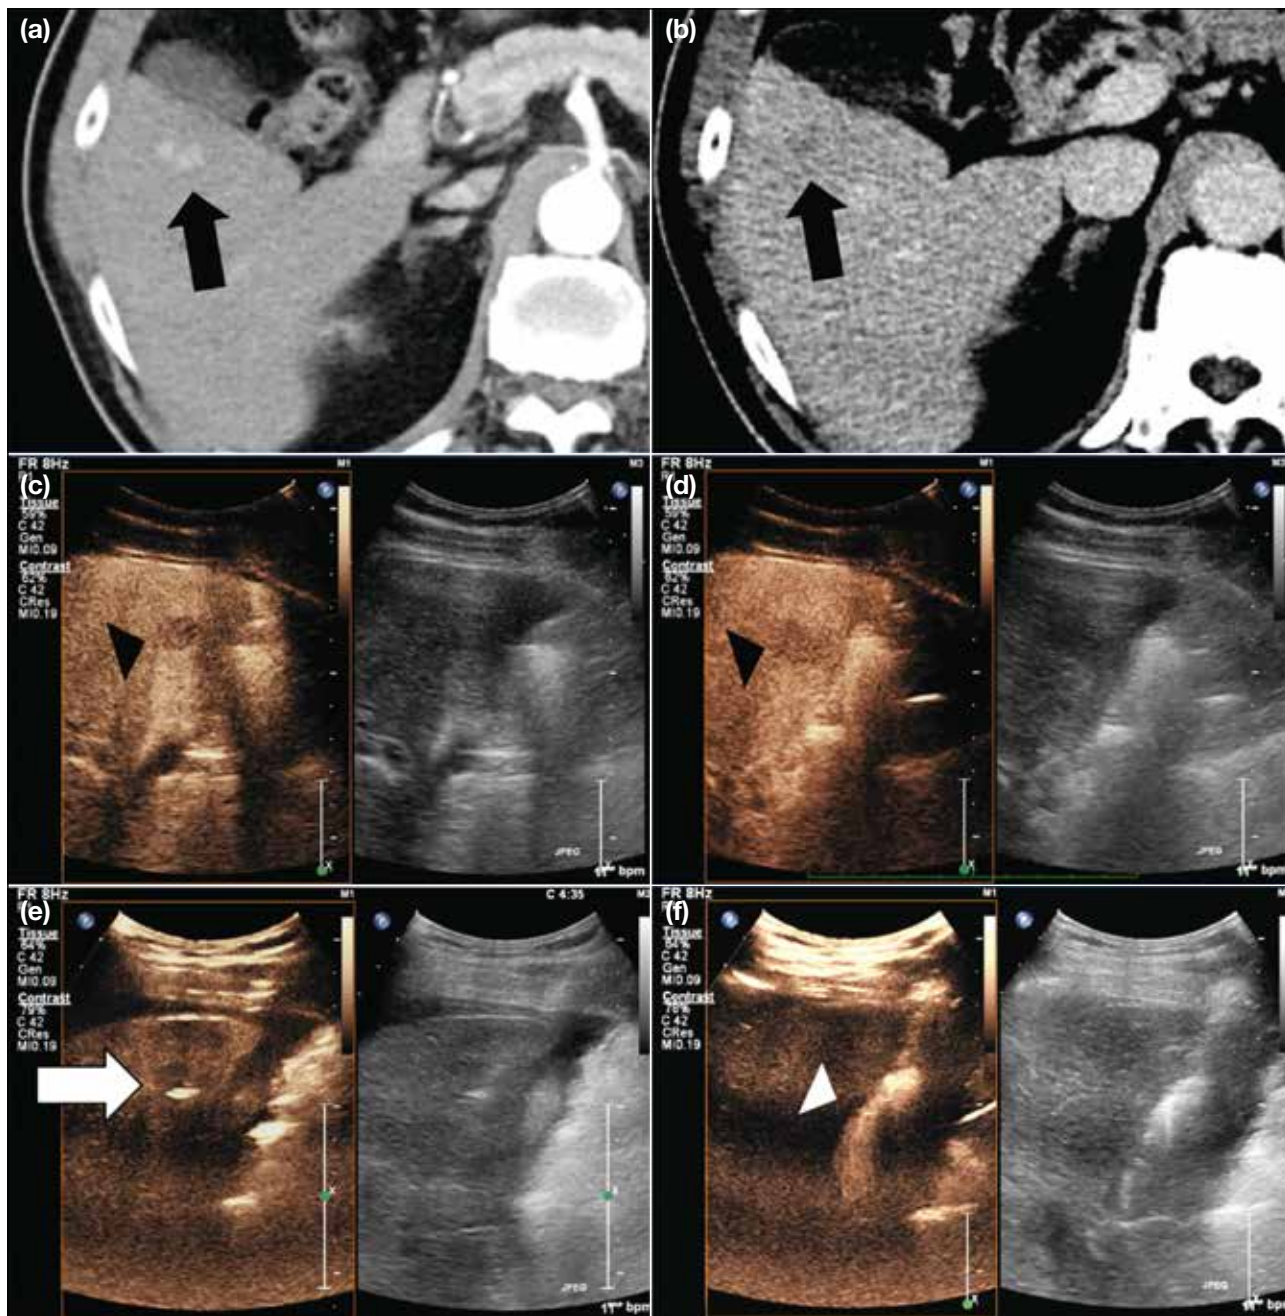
This patient had chronic hepatitis B viral infection and cirrhosis. (a and b) Axial contrast computed tomography (CT) liver showed two small arterial enhancing lesions in segment V of the liver with contrast washout in the delayed phase suspicious for hepatocellular carcinoma (black arrows). (c and d) The patient was referred to our team for percutaneous ablation of the lesions. On conventional B-mode (brightness mode) ultrasound, both of the lesions could not be well visualised (image not captured). Contrast-enhanced ultrasound (CEUS) with Sonazoid was then performed, with two nodular parenchymal defects in segment V of liver closely abutting each other during the Kupffer phase corresponding to the CT-detected lesions (black arrowheads). (e and f) Subsequent percutaneous ablation was performed under CEUS with Sonazoid during the Kupffer phase. The lesions were first targeted with a 22G spinal needle (white arrow) and then a microwave antenna was inserted with parallel technique under CEUS guidance (white arrowhead).
